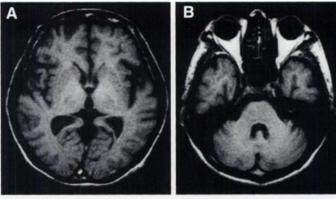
Axial MRI T1 weighted image at the level of (A) basal ganglia and (B) cerebellum shows mild brain atrophy. No abnormal signal intensity is detected.
